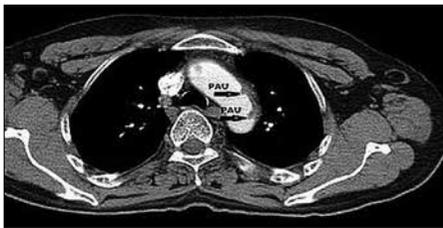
CT scans of penetrating atherosclerotic ulcer located in the arcus aorta
